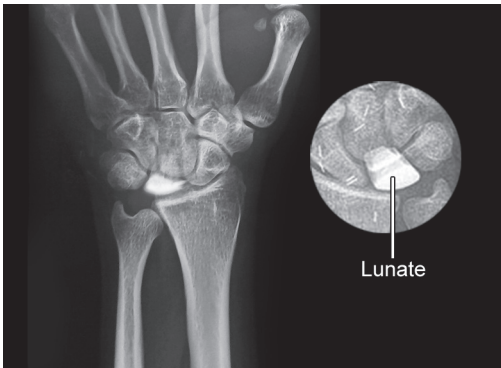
X-ray: Kienbock's disease (lunate)
